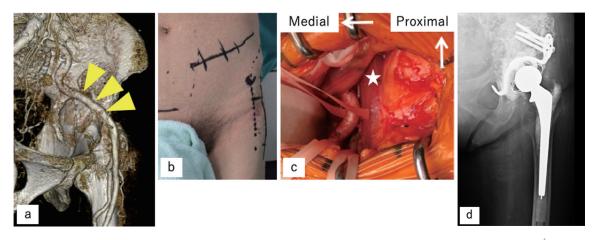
Case 1. a. Anteromedial view of the left pelvis in 3D CT angiography. The external iliac artery (yellow arrowhead) was displaced superiorly due to compression of the migrated cup. b. Anterior view of the left abdomen and groin on a traction table. An oblique skin incision line parallel to the inguinal ligament was marked at the left lower abdomen, starting from the midpoint between the umbilicus and pubic symphysis. c. Operative view through the retroperitoneal approach. A tape was passed around the mobilized external iliac artery located medially on the iliopsoas muscle belly (white star). d. Postoperative anteroposterior radiograph showing the reconstructed left hip using a Kerboull cross-plate, structural allograft, and cemented cup.
